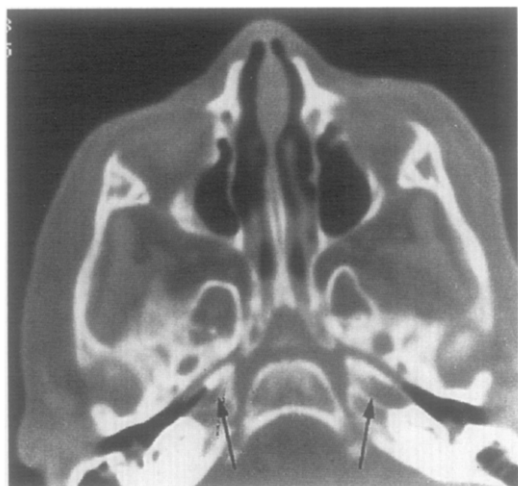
Computed tomography shows the development of bilateral carotid foramina (arrows).
